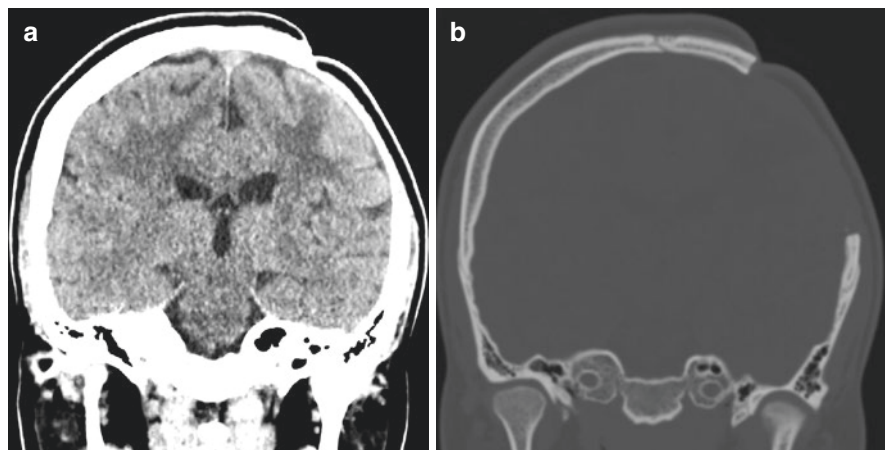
Acrylic cranioplasty in a 16-year-old girl after evacuation of an intracerebral hematoma caused by an arteriovenous malformation. Axial CT image obtained with brain window settings (a) shows the cranioplasty as a smooth region of high attenuation that is thinner than the calvaria. Axial CT image obtained with bone window settings (b) shows that the cranioplasty has lower attenuation than bone
